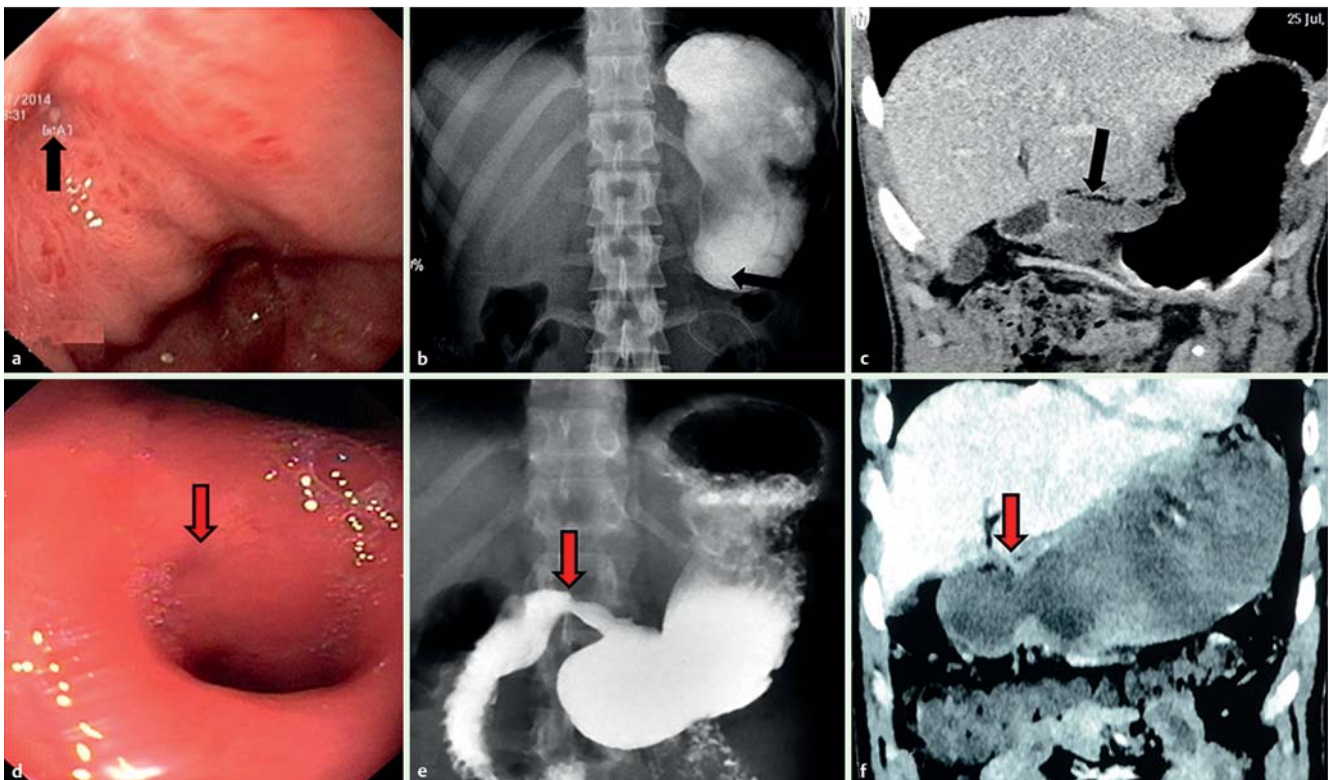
a–c Complete gastric outlet obstruction (black arrow) visualized by: a endoscopy; b barium study; and c computed tomography (CT). d–e The opened up pyloric orifice following dilation (red arrow) visualized by: d endoscopy; e barium study; and f CT.
